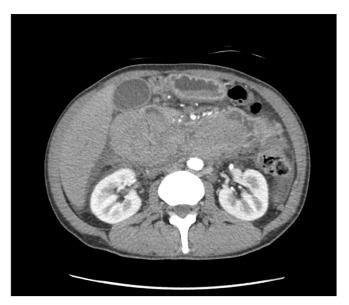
CT scan with arterial contrast does not show any contrast extravasation ruling out active bleeding.
